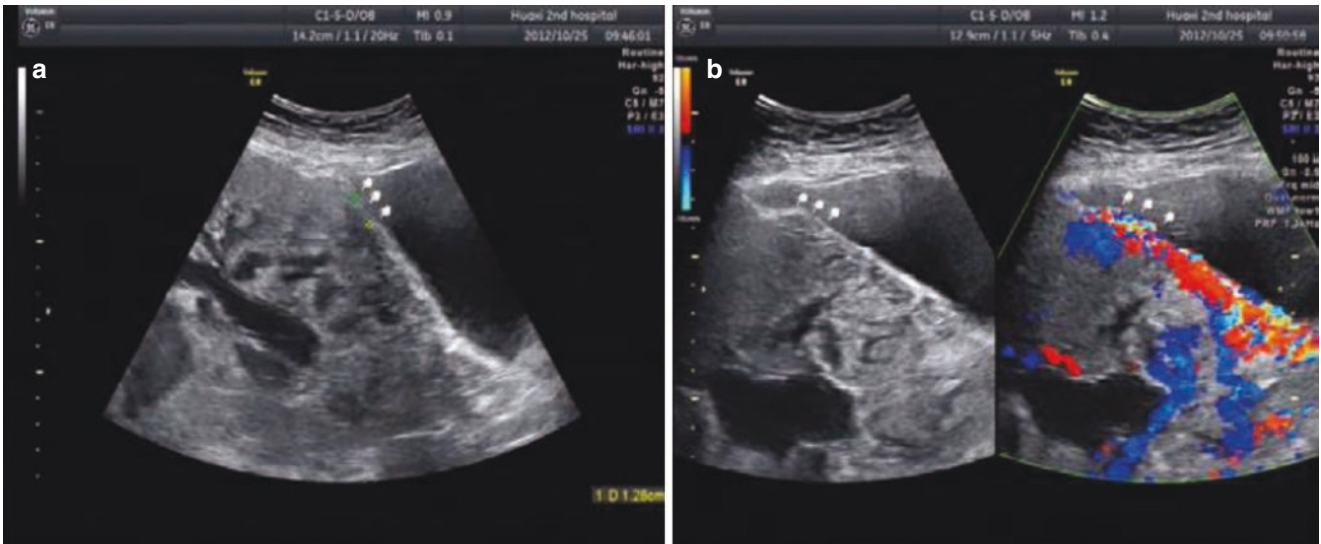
Pernicious placenta previa. (a). 2-D Sonogram shows the vortex formation in placenta and the thinned vesica peritoneal extension. (b). Color Doppler flow imaging shows abundant blood vessels in the vesical peritoneum
